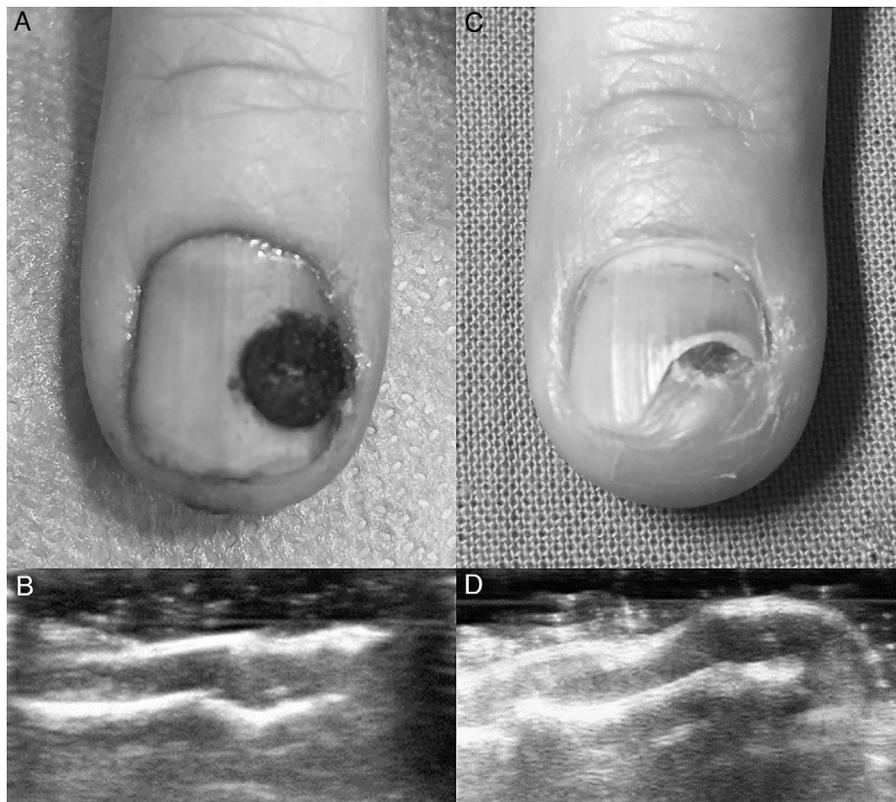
A, Outcome immediately after surgery. B, Ultrasound confirmation of tumor resolution. C, Clinical outcome 2 weeks after surgery. D, Ultrasound confirmation 2 weeks after tumor excision.
